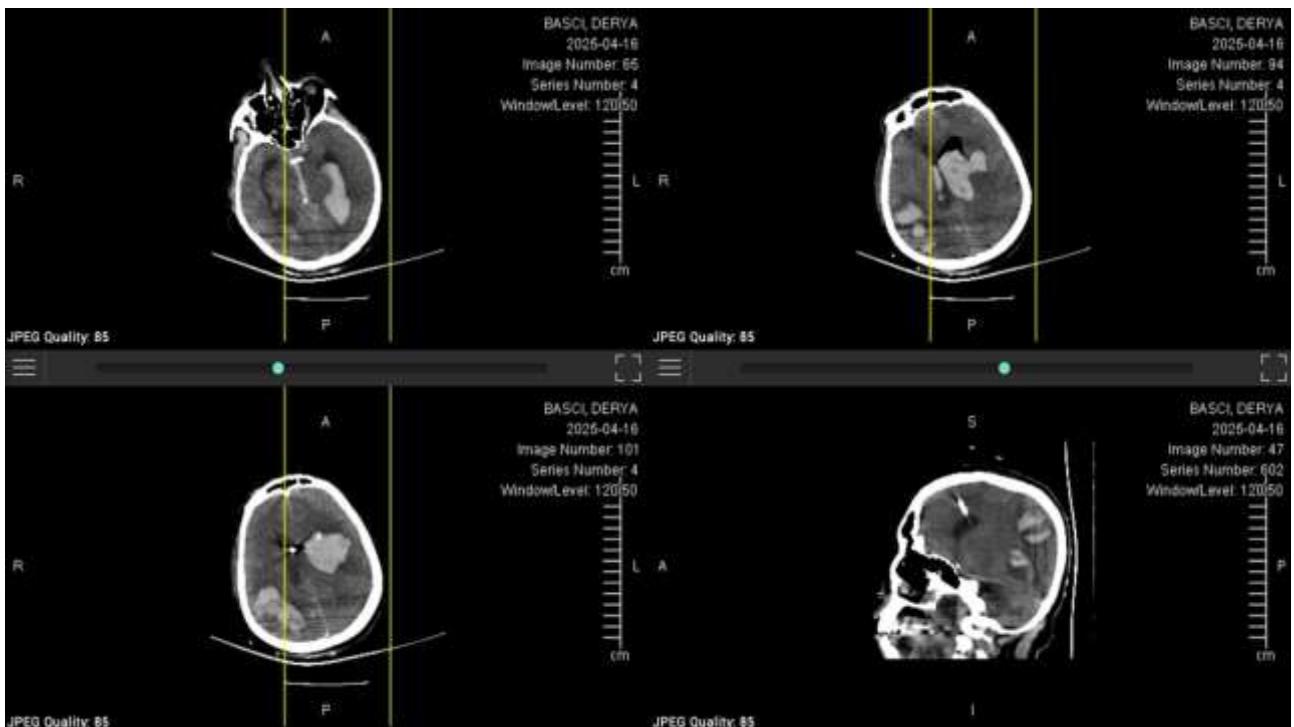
Control non-contrast cranial CT showing external ventricular drainage catheters and extensive bilateral hemorrhage with subarachnoid involvement.
